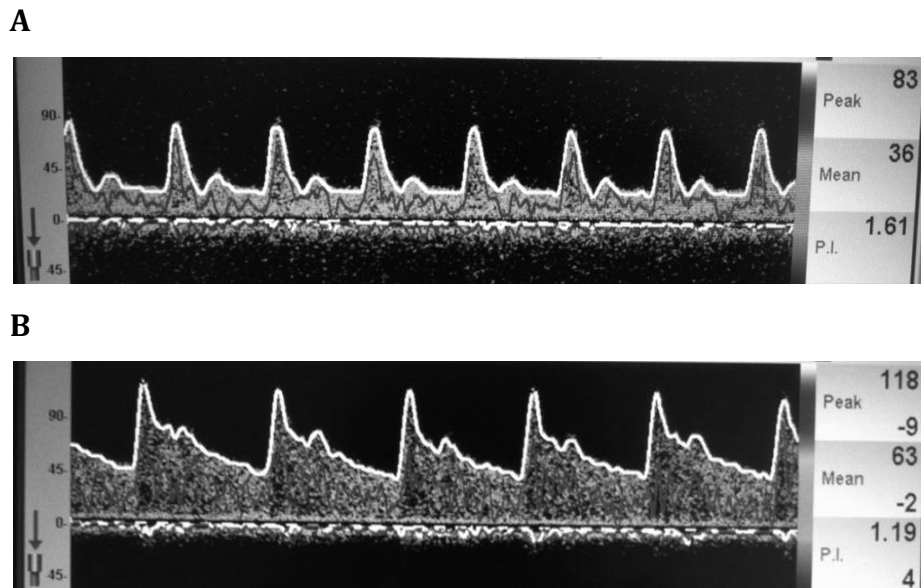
TCD of a 17 year-old boy with hydrocephalus and inconclusive CT scan that was operated based on an increased pulsatility index (PI) of 1.61 (A). After reviewing the ventricular shunt the PI normalized (B).
